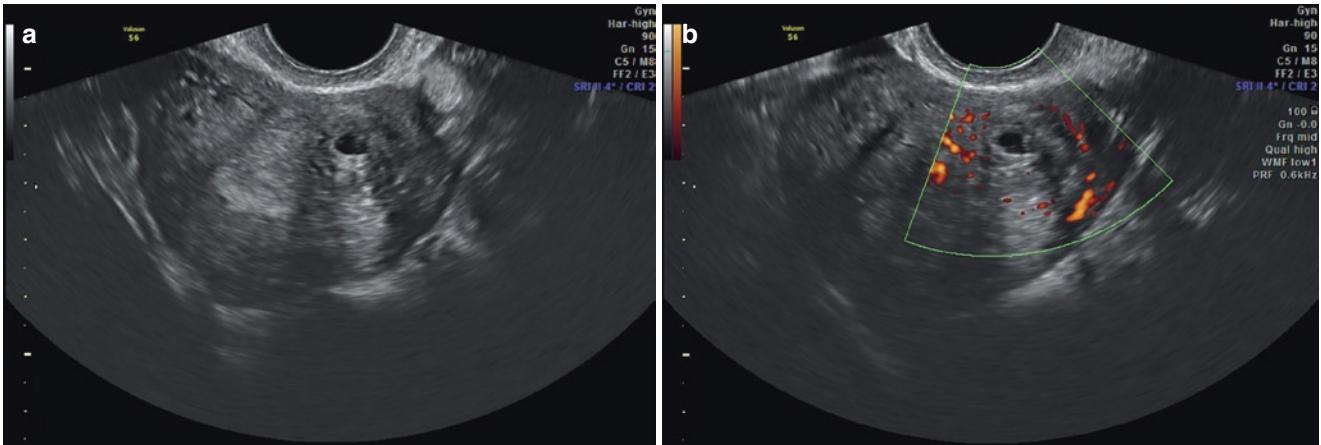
Transvaginal transverse image of the uterus. (a) Grayscale shows a degenerated myoma as a well-circumscribed nodule with central cystic area. (b) Color Doppler sonogram of the same image shows the presence of straight vessels traversing a hyper-trophic myometrium
